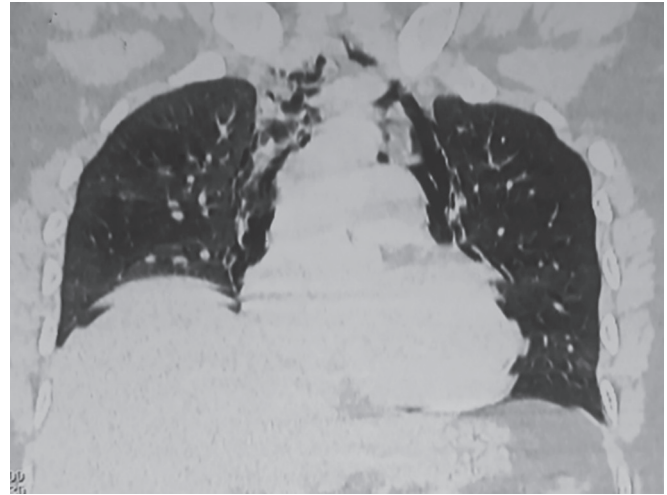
Coronal section HRCT chest revealing, pneumomediastinum
